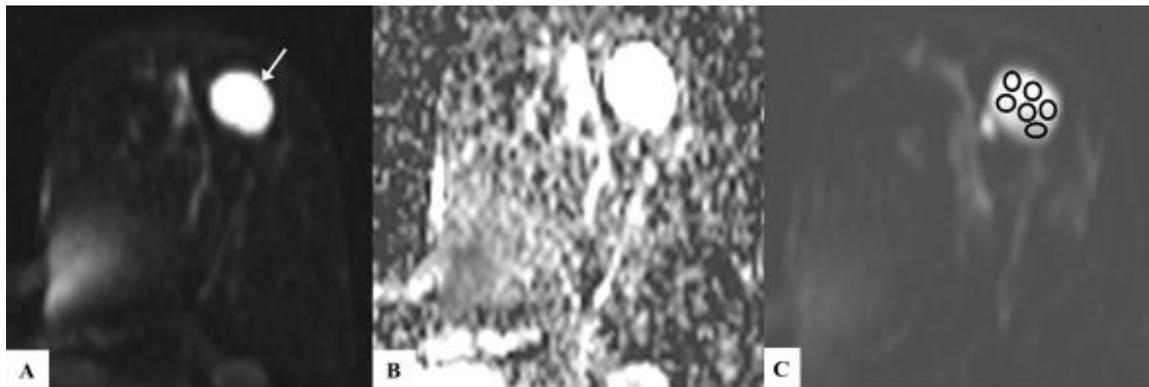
Benign breast lesion –A) DWI image showing a well-defined ovoid hyperintense lesion in left breast parenchyma (white arrow). B) ADC sequence showing no restricted diffusion of the lesion. C) Calculation of mean ADC value- Multiple ovoid ROI each measuring  $\sim 25 \text{ mm}^2$  are placed throughout the lesion on DWI sequence; ADC value of each ROI is calculated and mean ADC value of all the ovoid ROI is considered as final value. The lesion was diagnosed as fibroadenomas. (ADC – Apparent diffusion coefficient, DWI – Diffusion weighted image, ROI – region of interest).
